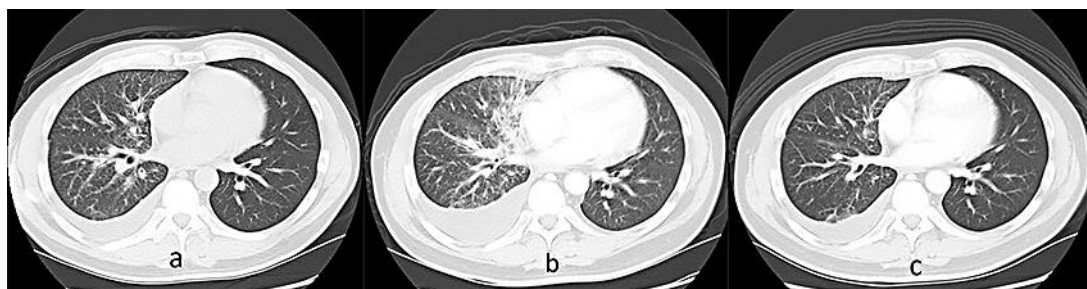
Sequential chest CT scans showing the changes in right pulmonary lymphangitic carcinomatosis and right pleural effusion. a Before treatment. b After 1 cycle of first-line therapy with cisplatin and pemetrexed. c After 1 cycle of bevacizumab plus cisplatin and pemetrexed.
